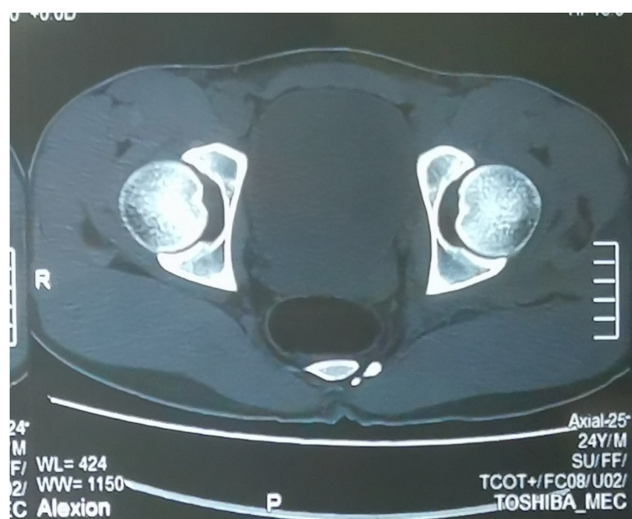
Pelvic CT scan excludes any intra-articular fragments or associated fracture.
